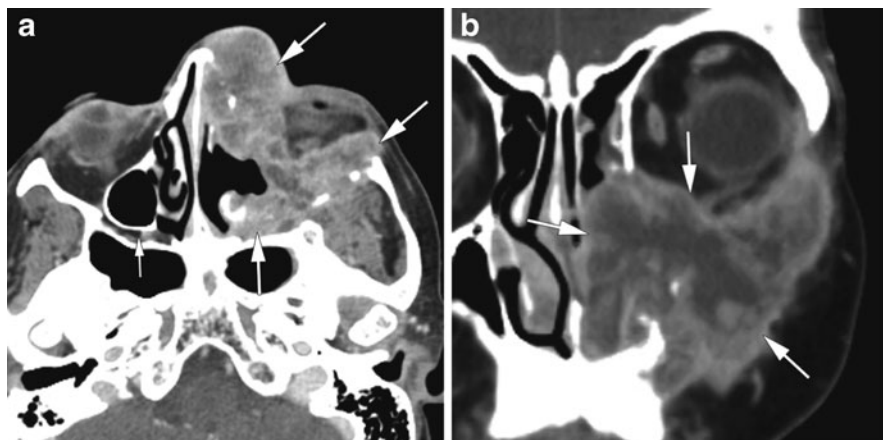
Adenoid cystic carcinoma, left maxillary sinus. (a) Axial postcontrast CT image demonstrates a mass involving the left orbit, peri-orbital soft tissue, and pterygopalatine fossa (*large arrows*). Note the normal right pterygopalatine fossa (*small arrow*). (b) Coronal postcontrast CT image shows an invasive left maxillary sinus mass with destruction of the orbital floor (*arrows*)
